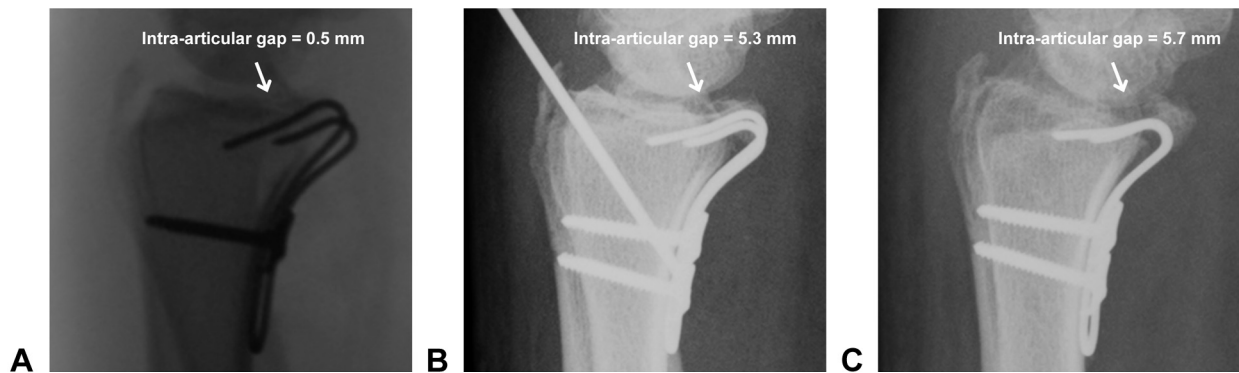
Radiographic change in a 48-year-old man who had undergone open reduction internal fixation with a fragment-specific construct and K-wire fixation for an AO 23-B3–type fracture. Although the intraoperative series showed A an intra-articular gap of 0.5 mm, the early and late postoperative series showed intra-articular gaps of B 5 mm and C 6 mm, respectively. The development of this intra-articular gap was associated with volar displacement of the volar rim.
